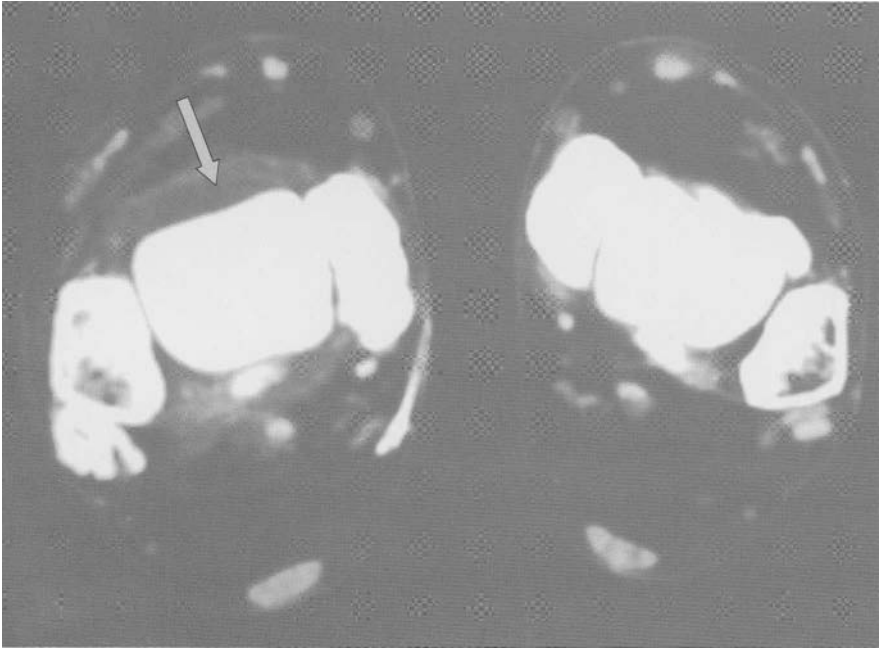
CT: soft tissue window. Right talo-crural rheumatoid pannus (arrow).
